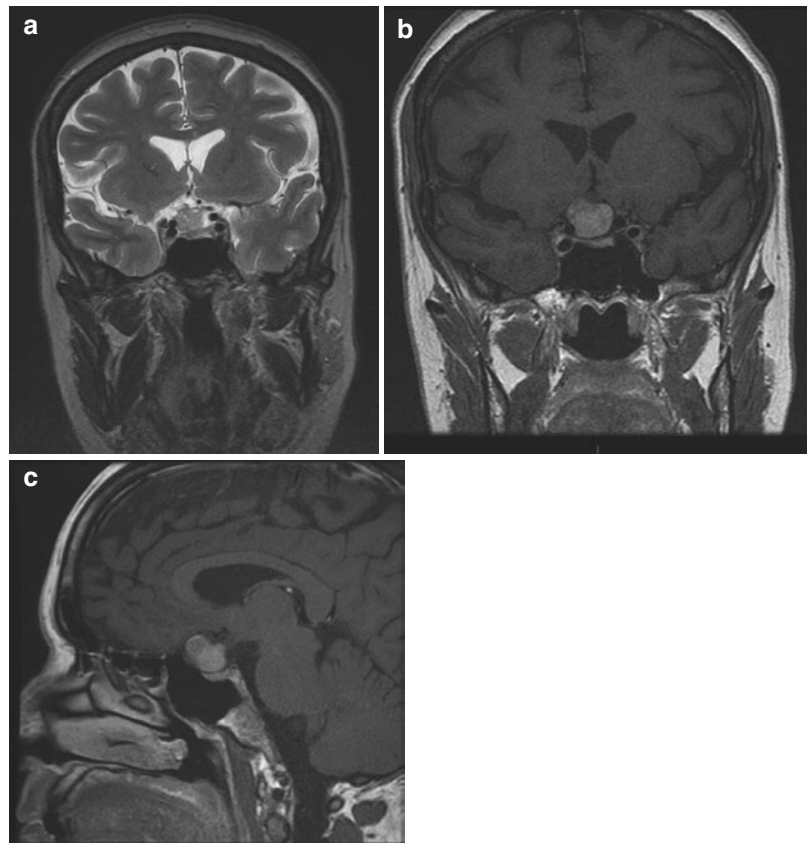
MRI: (a) T2 weighted and (b) T1 weighted contrast enhanced coronal scans showing a large lesion which is separate from the anterior pituitary and displaces the stalk to the left. The pituitary fossa is not enlarged (c). It appears to be arising from the right optic nerve. The lesion exhibits uniform enhancement with Gadolinium
